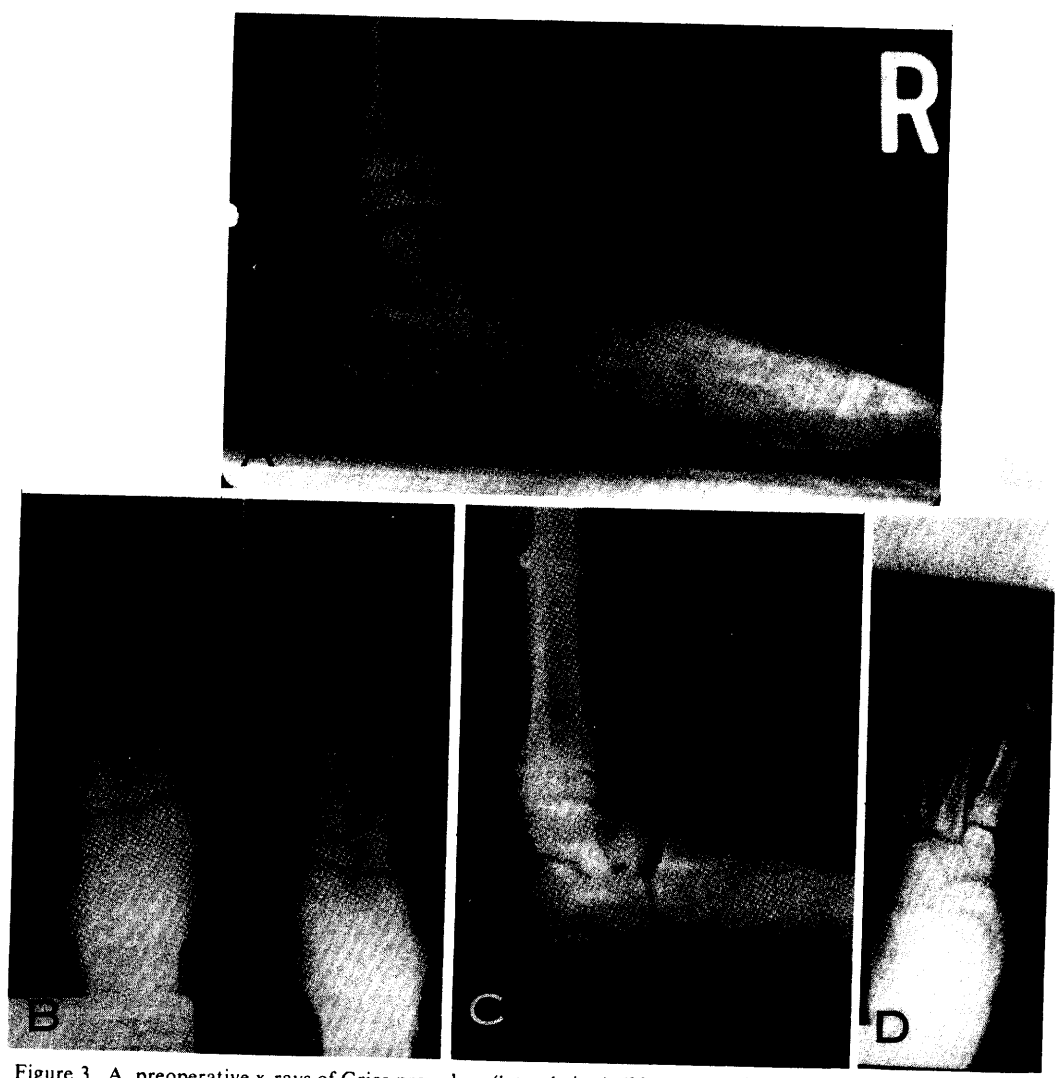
A, preoperative x-rays of Grice procedure (lateral view). (Note marked declination angle of the talus and subluxatory changes occurring at the subtalar and midtarsal joints.) This patient was previously treated with soft tissue procedures for the correction of flatfoot which had failed. B, preoperative dorsoplantar x-ray of the foot. (Note marked dislocation of Chopart's joint. Also note that less than 50% of the talus articulates with the navicular.) C, lateral x-ray after Grice procedure. (Note marked and pronounced reduction of the deformity with the extra-articular arthrodesis, placement of the bone graft approximately perpendicular to the axis of motion of the subtalar joint, and placement of the transfixing screw to stabilize the lower one-third of the fibula to tibia.) D, dorsoplantar view after Grice procedure. (Note placement of the graft on the dorsoplantar view and marked reduction of the dislocation at Chopart's joint. Also note that greater than 75% of the talus now articulates with the navicular.)
